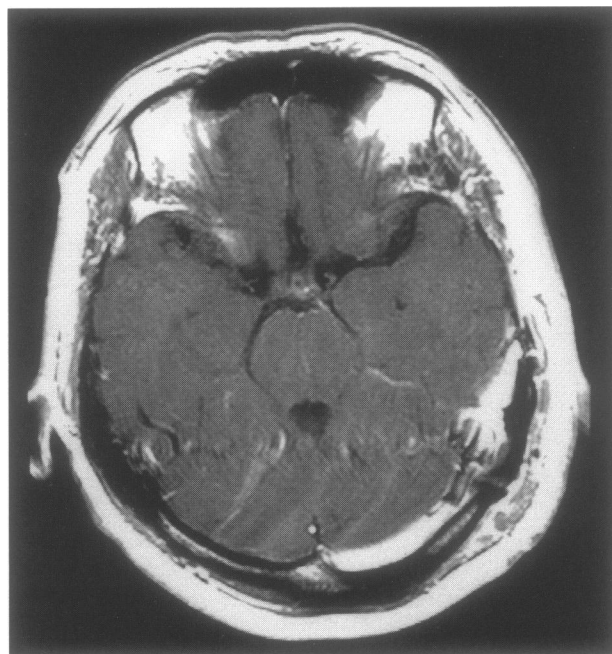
Postoperative MRI in Case 2.
